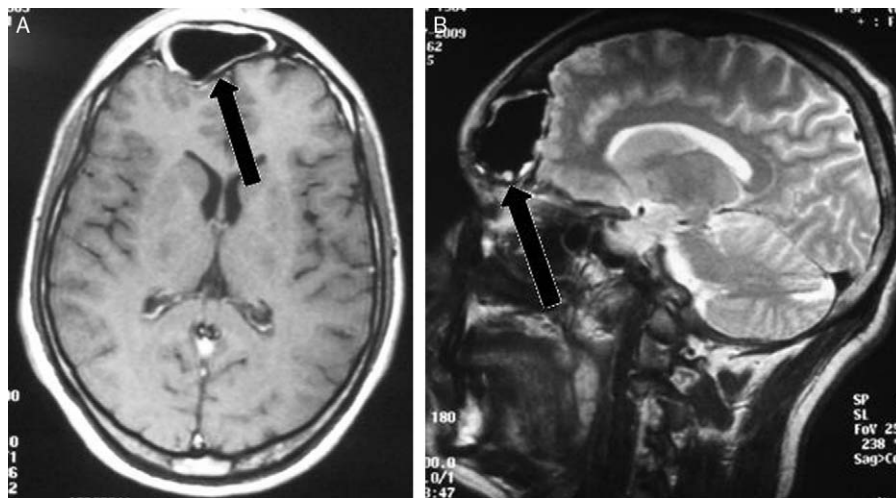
Cranial MRI after 2 months postoperatively showing good pneumatization of the frontal sinus without recurrence (arrow). A. T1-weighted imaging sequence after intravenous contrast in axial section. B. T2-weighted imaging sequence in sagittal section.
